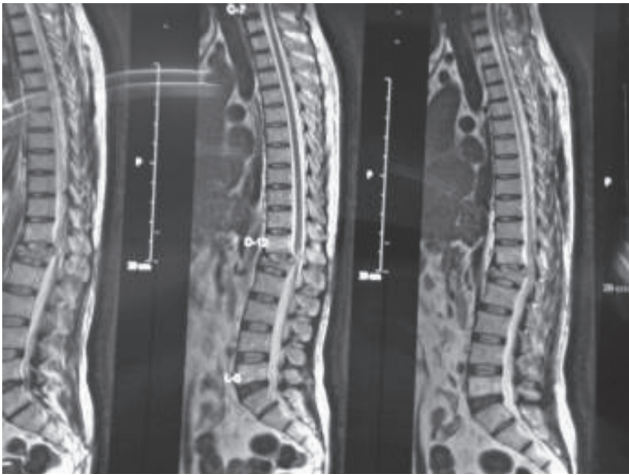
Magnetic resonance imaging (MRI) of same patient.
